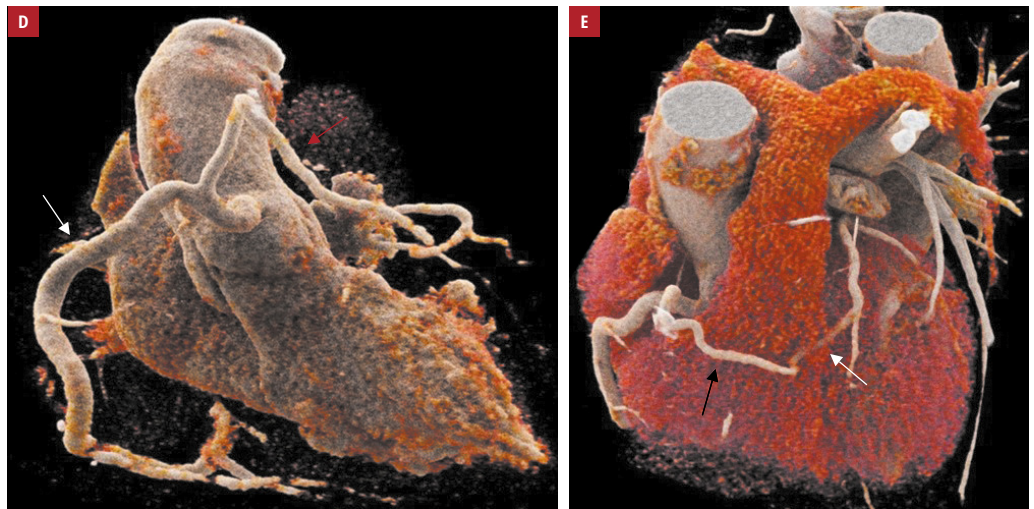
Computed tomography angiography showing: D – the dominant RCA originating from the right SoV (white arrow), LAD (red arrow); E – LAD (black arrow) located anterior to the pulmonary trunk with myocardial bridging (white arrow).
